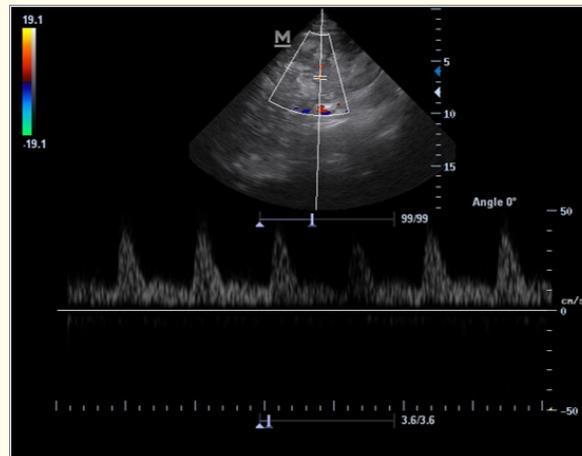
Forward diastolic flow above baseline in spectral Doppler of splenic artery.
